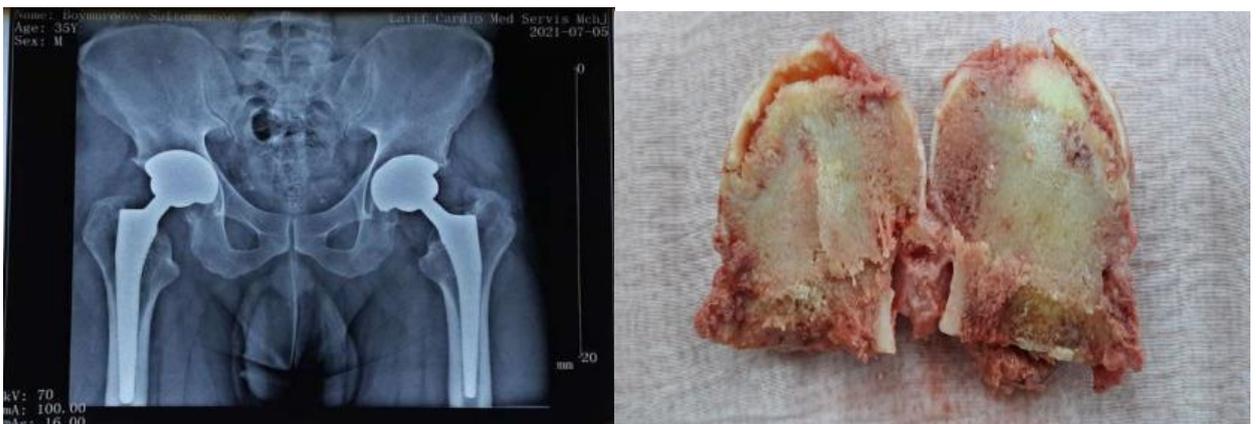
C. Patient B.S. 1986 No. IB 303/67 with aseptic necrosis of the head of both femurs IV degrees. X-ray of the patient after endoprosthetics surgery and macropreparation (femoral head).
